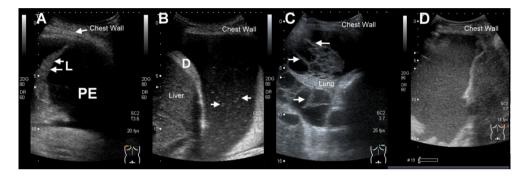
Sonographic appearance of pleural effusion (PE). The effusion can be subclassified as anechoic (A), complex nonseptated with spots(arrows) floating inside effusion. D, diaphragm (B), complex septated (arrows) (C), and homogenously echogenic (D)
